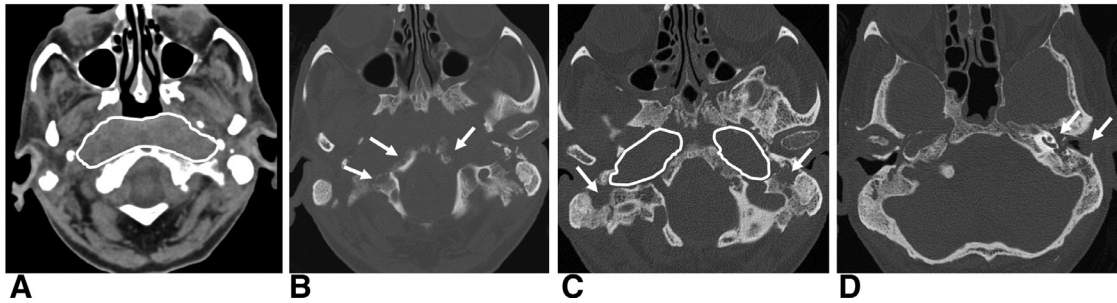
Axial CT soft tissues (A) and High resolution Temporal bone images (B-D). Confluent inflammatory prevertebral and posterior nasopharyngeal soft tissue thickening along the skull-base (A-white contours). Central skull-base erosion of petrous and occipital bones (B-arrows). Note erosive holes in inferior mastoid temporal bones (C-arrows). Bilateral “Ovoid” appearing gap between the bones at the central skull-base due to expansile and erosive soft tissue thickening (C-white contours). Left otomastoid and external ear nonerosive opacification (D-arrows).
